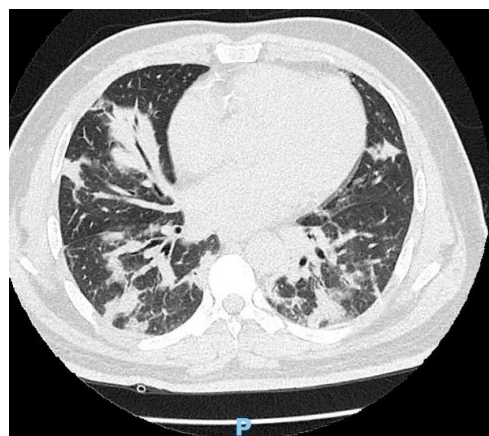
CT chest showing areas of consolidation bilaterally mainly rt lung lobes.
